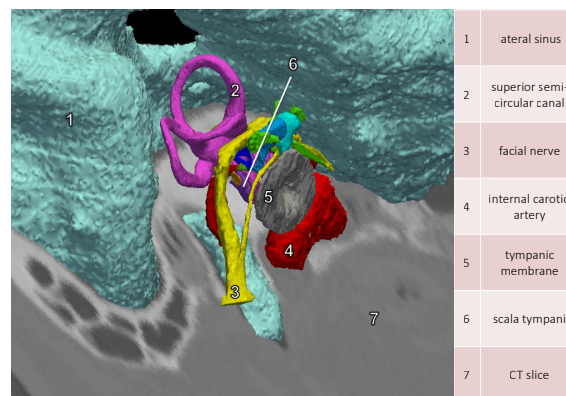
Virtual view of the posterior tympanotomy approach fused with a CT-scan
